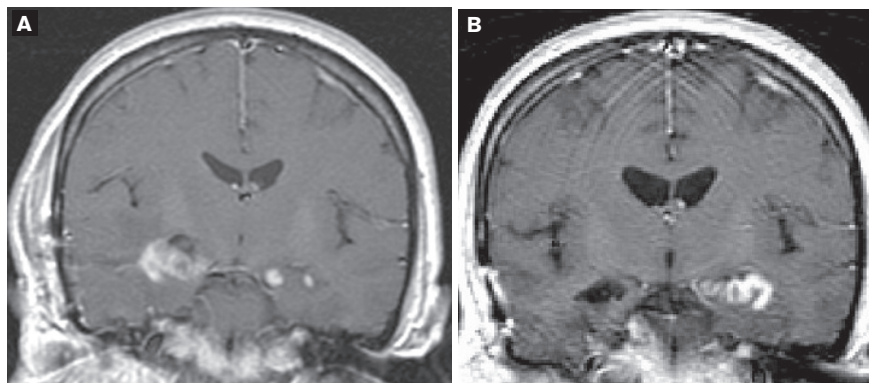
A: Coronal T1-weighted MRI 4 months after the onset of symptoms shows gadolinium enhancement of the mesial temporal lobe lesions. B: A similar view at 7 months shows postoperative changes in the right temporal lobe.
